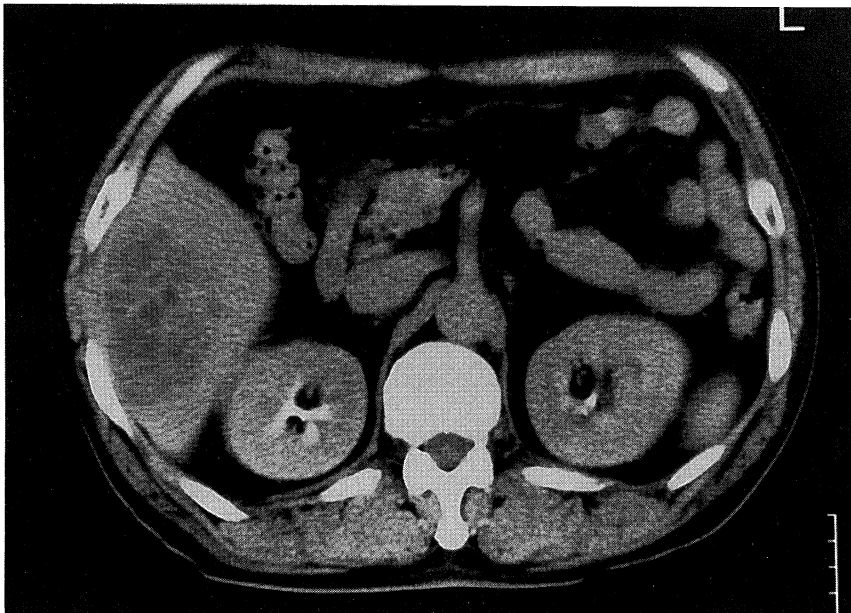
Computed tomography showing a 8.0×5.0 cm low density mass with inhomogenous pattern.
